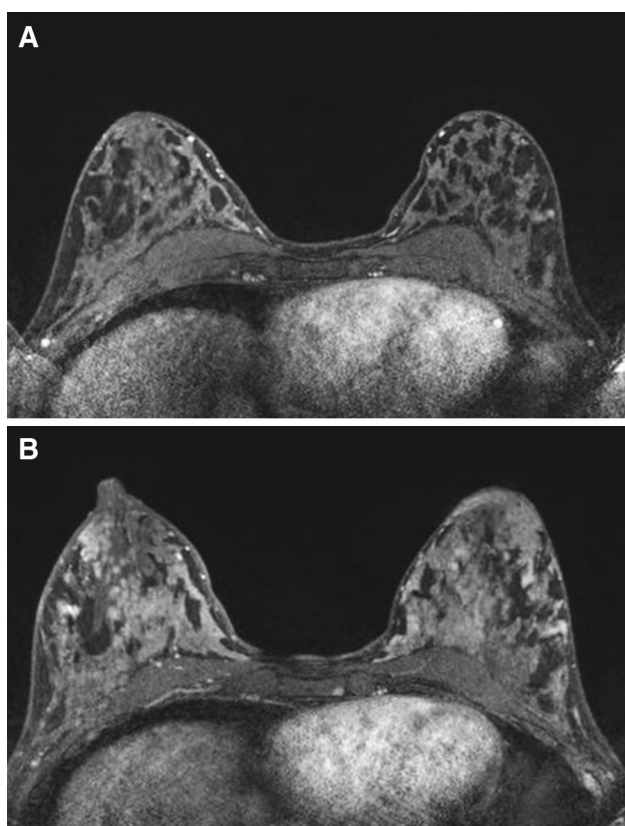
a Axial T1-weighted post-gadolinium breast MRI shows the normal baseline appearance of the patient's bilateral breasts. b Axial T1-weighted post-gadolinium breast MRI 1 year later shows increased breast density and increased background parenchymal enhancement in both breasts, compatible with lactational state
